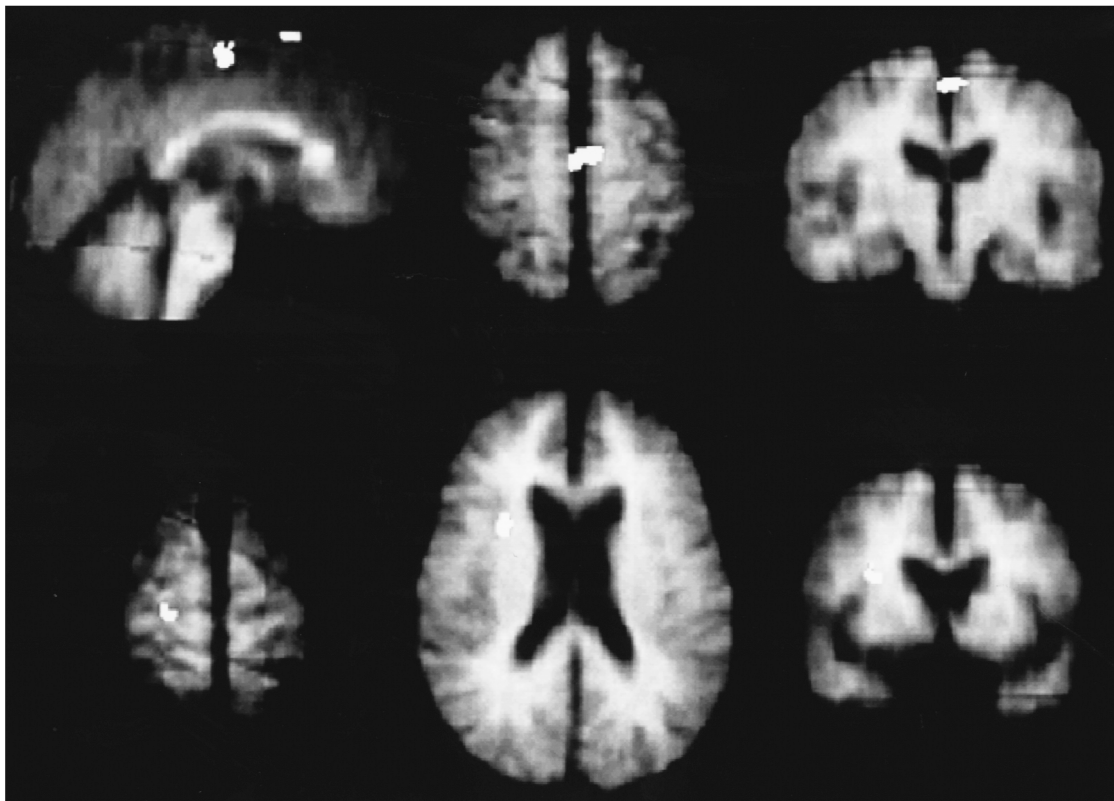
Areas with significant post-pallidotomy blood flow increases during movement are shown in white, superimposed on patients' average MRI. Increases are seen in SMA (top row), premotor cortex and anterior insula (bottom row). Reprinted with permission from Grafton et al., 1995.
